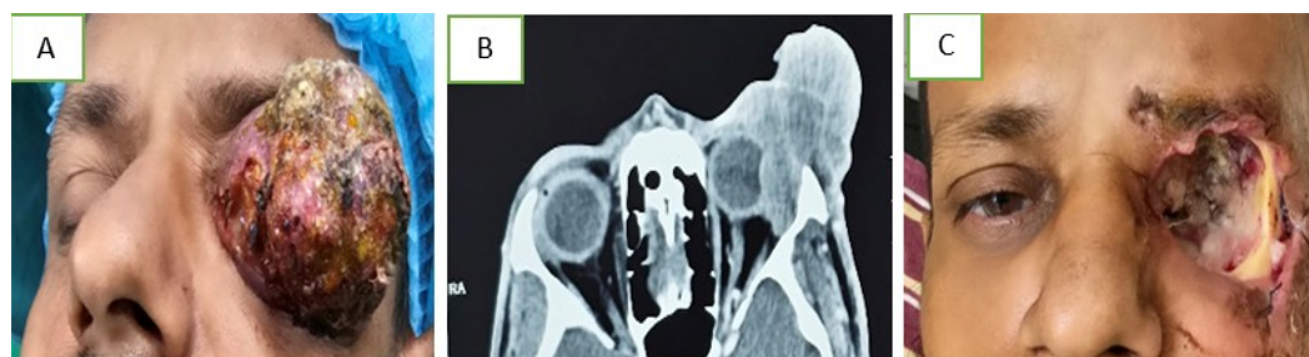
A. Extensive sebaceous gland carcinoma arising from left upper eyelid B. CT Scan Axial view showing orbital extension of carcinoma. C. Post- Exenteration Photograph
